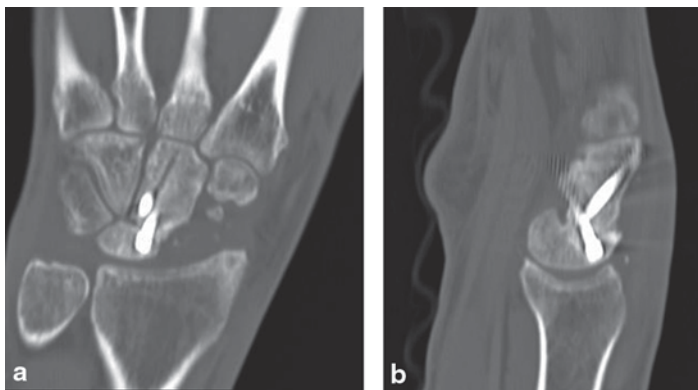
a Coronal CT scan image showing bridging bone across the CL joint. b Sagittal CT scan image showing bridging bone across the CL joint. (Published with kind permission of ©R. Glenn Gaston, 2015. All Rights Reserved)
